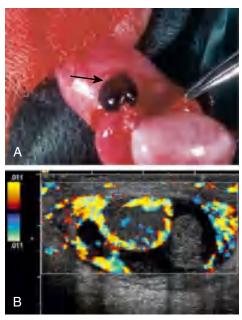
A, Torsion of the appendix testis; the appendix testis is necrotic (arrow). B, Color Doppler scrotal sonogram showing hyperemia to the testis and absent flow to the appendix testis (right side). Symptoms resolved with medical therapy.
